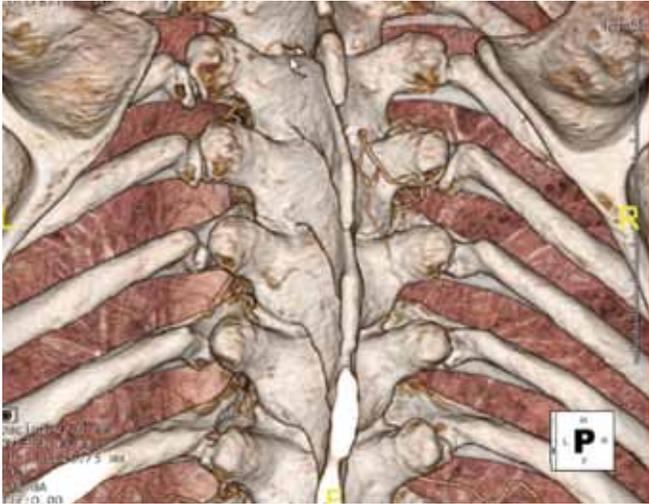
The Artery of Adamkiewicz identified by Dr. Sam Henly. Magnified virtual surgical table view inside Plato's CAVE using Siemens flash CT scan study with TeraRecon, Inc. visualization.
